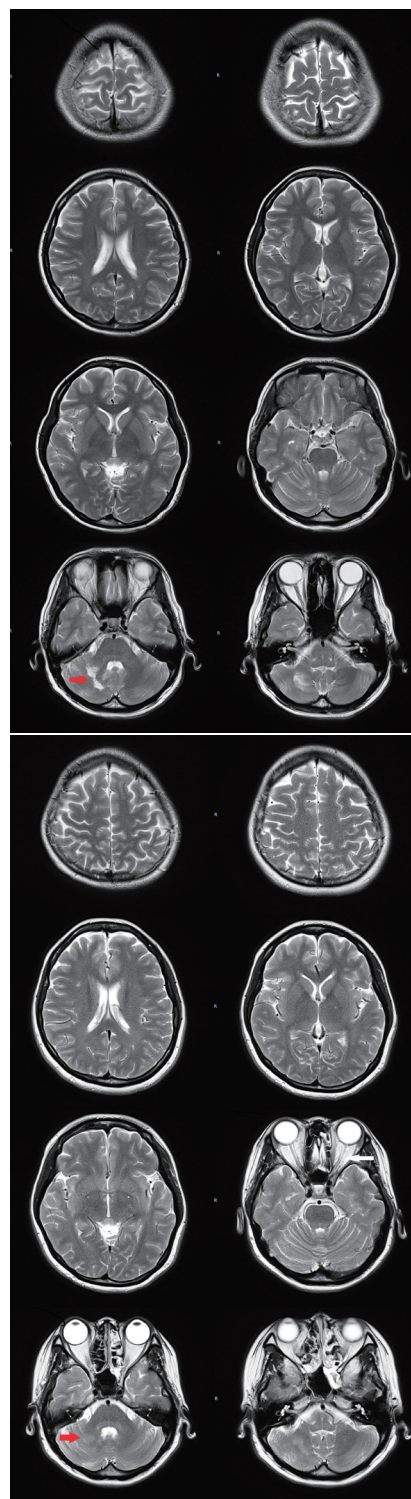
(left image): MRI brain in 2009 showed high T2 signal in the right cerebellum (red arrow).
